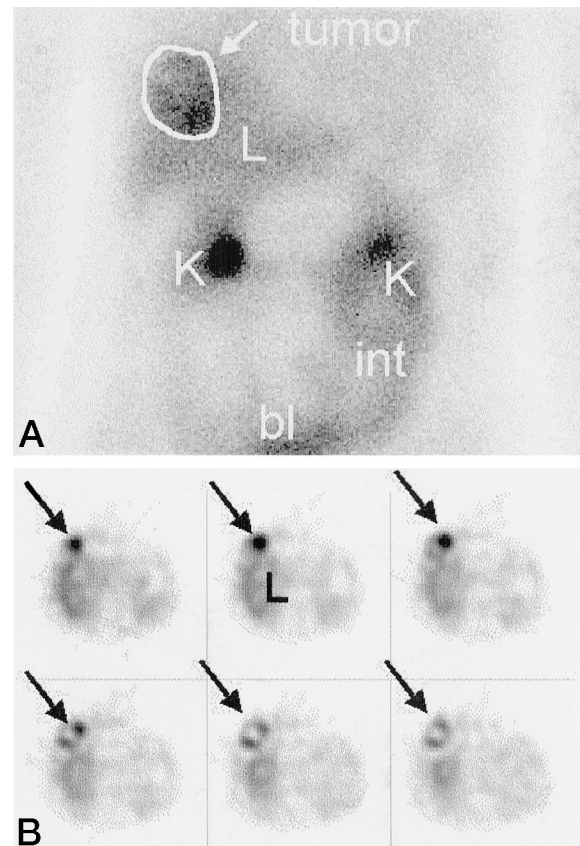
A, planar anterior image of the abdomen of patient 12 with a liposarcoma of the chest wall showing heterogeneous IMT uptake in a lesion that projects over the liver (circle and arrow). Physiological IMT uptake is present in the liver (L), both kidneys and pyela (K), intestine (int), and bladder (bl). B, transverse SPECT slices through the liver region (from cranial upper left to caudal lower right) better demonstrate the localization of the tumor (arrows) ventral of the liver (L), increased contrast and a central defect, presumably caused by tumor necrosis.
